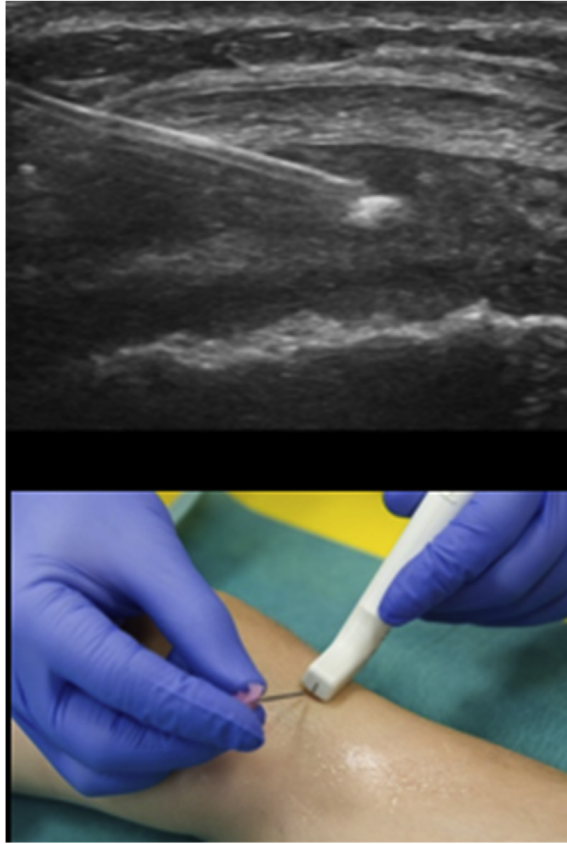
Injection of the infrapatellar bursa with ultrasound guidance.
